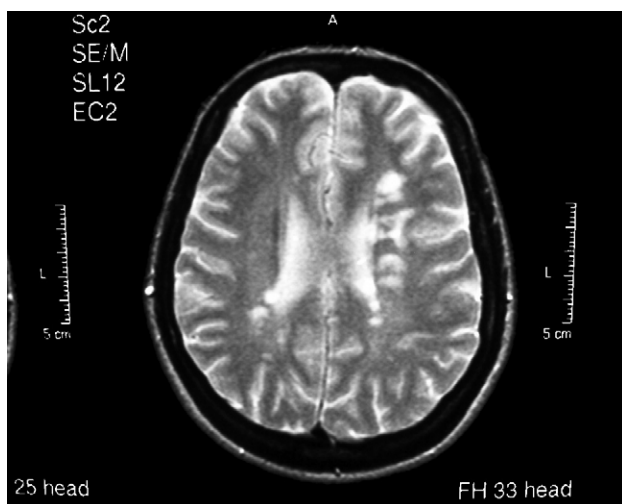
Axial T2-weighted MRI revealing multiple areas of abnormal high signal intensity involving deep white matter.
